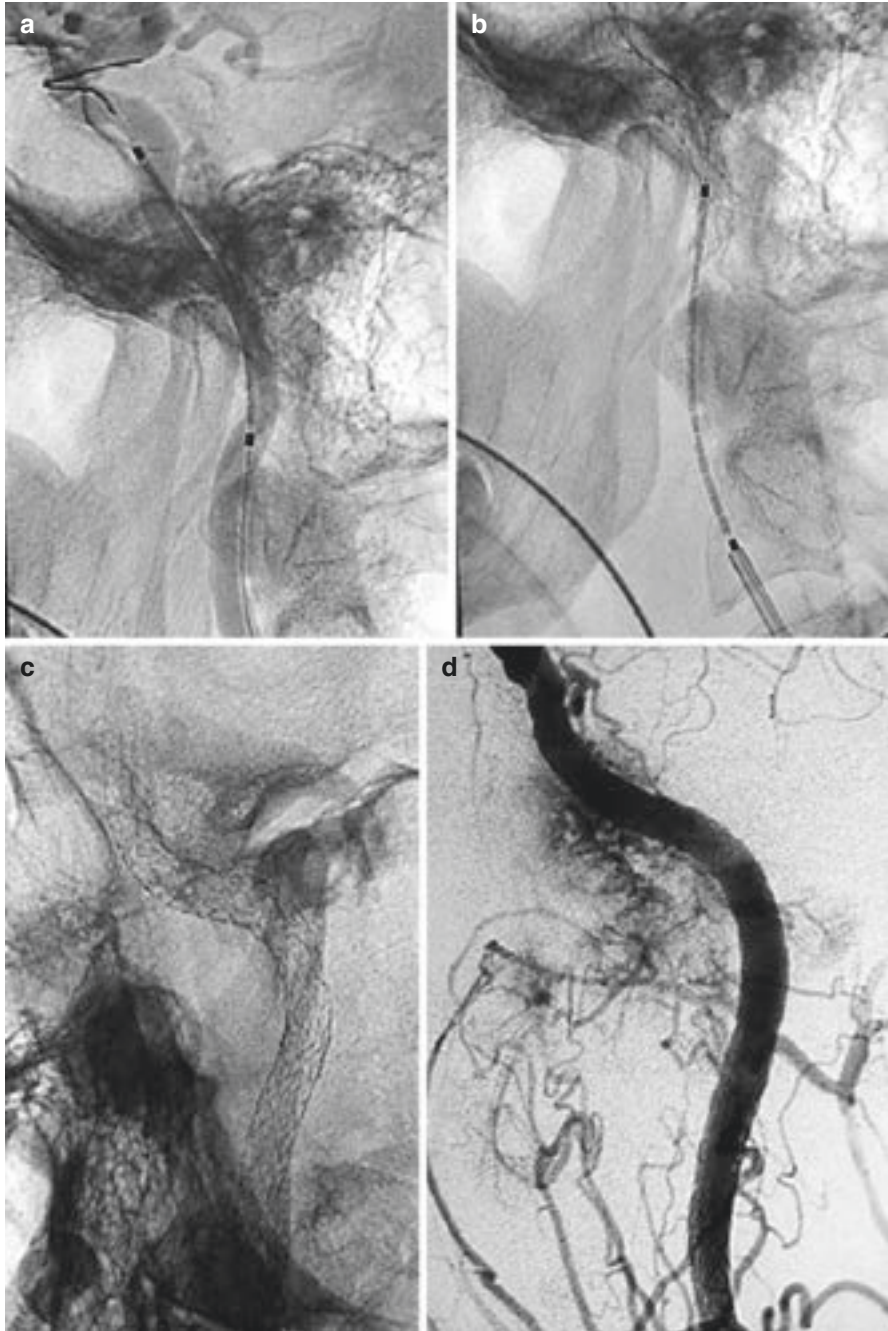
(a, b) Insertion of the stents in the petrous and cervical portions of the internal carotid artery (ICA). (c) Digital x-ray in oblique projection showing the stents fully deployed in the petrous and cervical segments of the ICA. (d) Digital subtraction angiography of the ICA after stenting showing resolution of the stenosis
